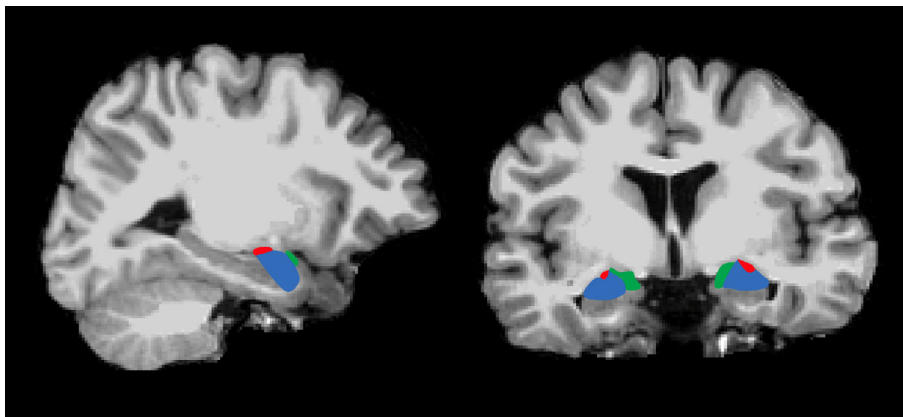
T1-weighted sagittal (left), and coronal (right) images showing location of the amygdala and three main subregions (SF = green, LB = blue, CM = red).
